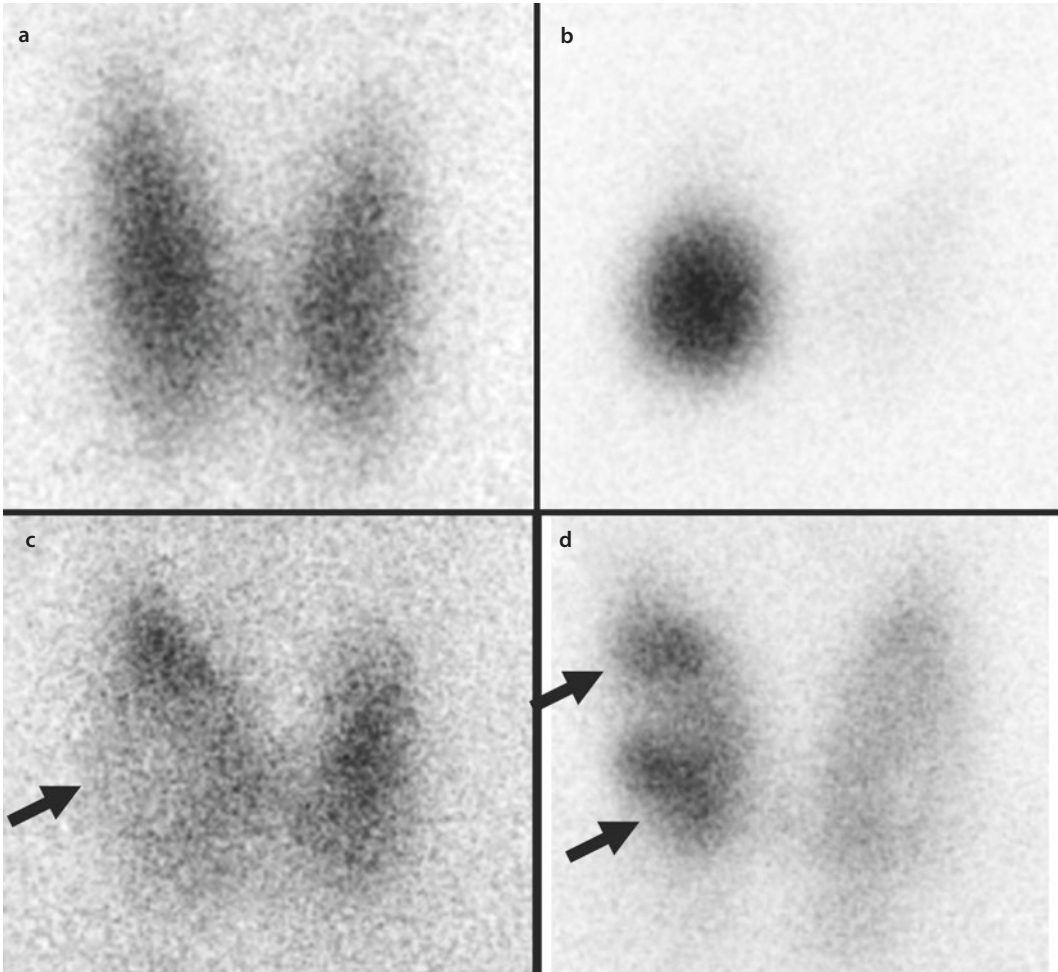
Thyroid scintigraphy (^{99m}Tc pertechnetate) imaging of thyroid nodules. a, normal thyroid; b, a hot nodule in the right lobe, with the rest of the thyroid suppressed (toxic adenoma); c, a cold nodule in the right lobe; and d, multiple nodules in the right lobe. The relevance of cold nodules (decreased isotope uptake) has
